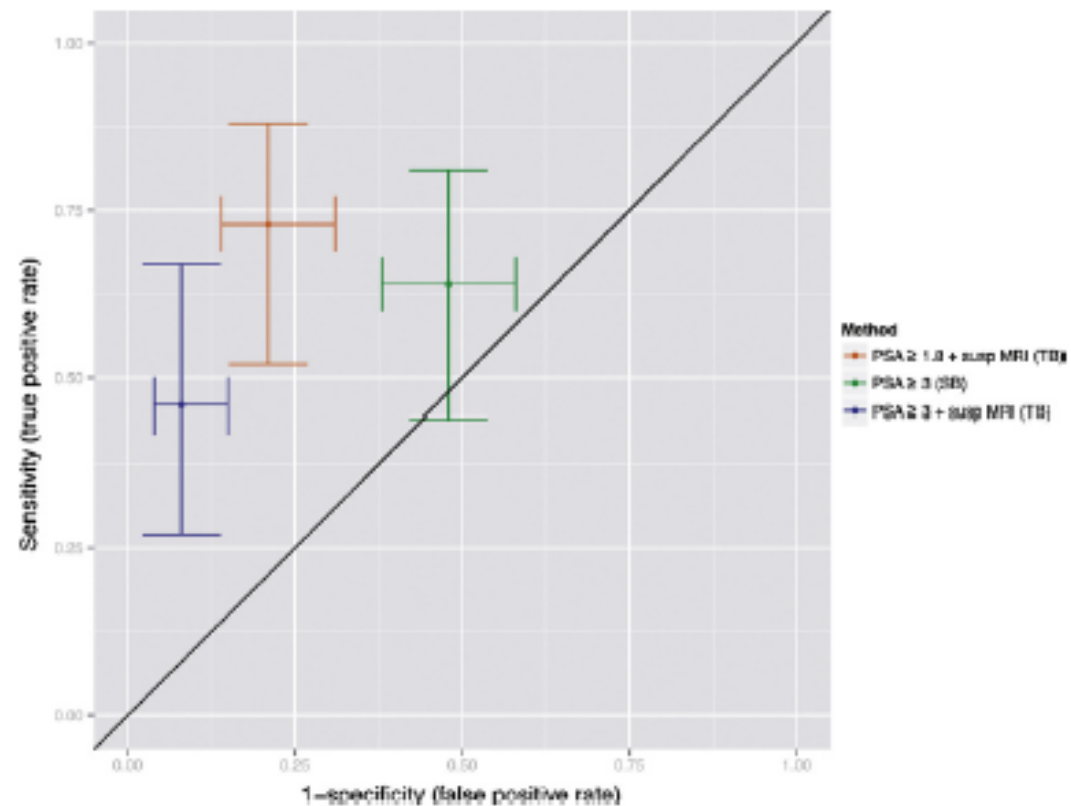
Estimated sensitivity and specificity of prostate cancer detection depending on screening strategy (prostate-specific antigen [PSA] ≥ 3 ng/ml followed by systematic biopsy, PSA ≥ 3.0 ng/ml followed by targeted biopsy, and PSA ≥ 1.8 ng/ml followed by targeted biopsy). Bars indicate 95% confidence intervals for sensitivity (y-axis) and 1-specificity (x-axis). PSA = prostate specific antigen; Susp MRI = suspicious magnetic resonance imaging (see 'Methods' for details); SB = systematic biopsy; TB = targeted biopsy.
